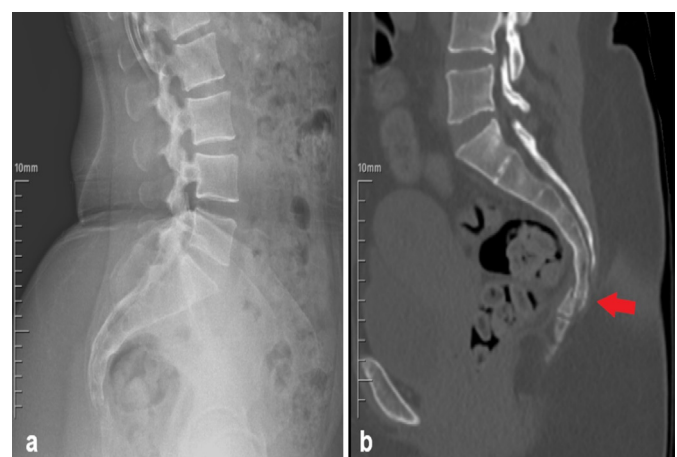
X-ray lateral view, oblique radiolucency in the second coccygeal segment suggestive of a fracture (a), Sagittal bone window reformat computed tomography, fracture of the second coccygeal segment, with minimally displaced fragments (red arrow) (b).
